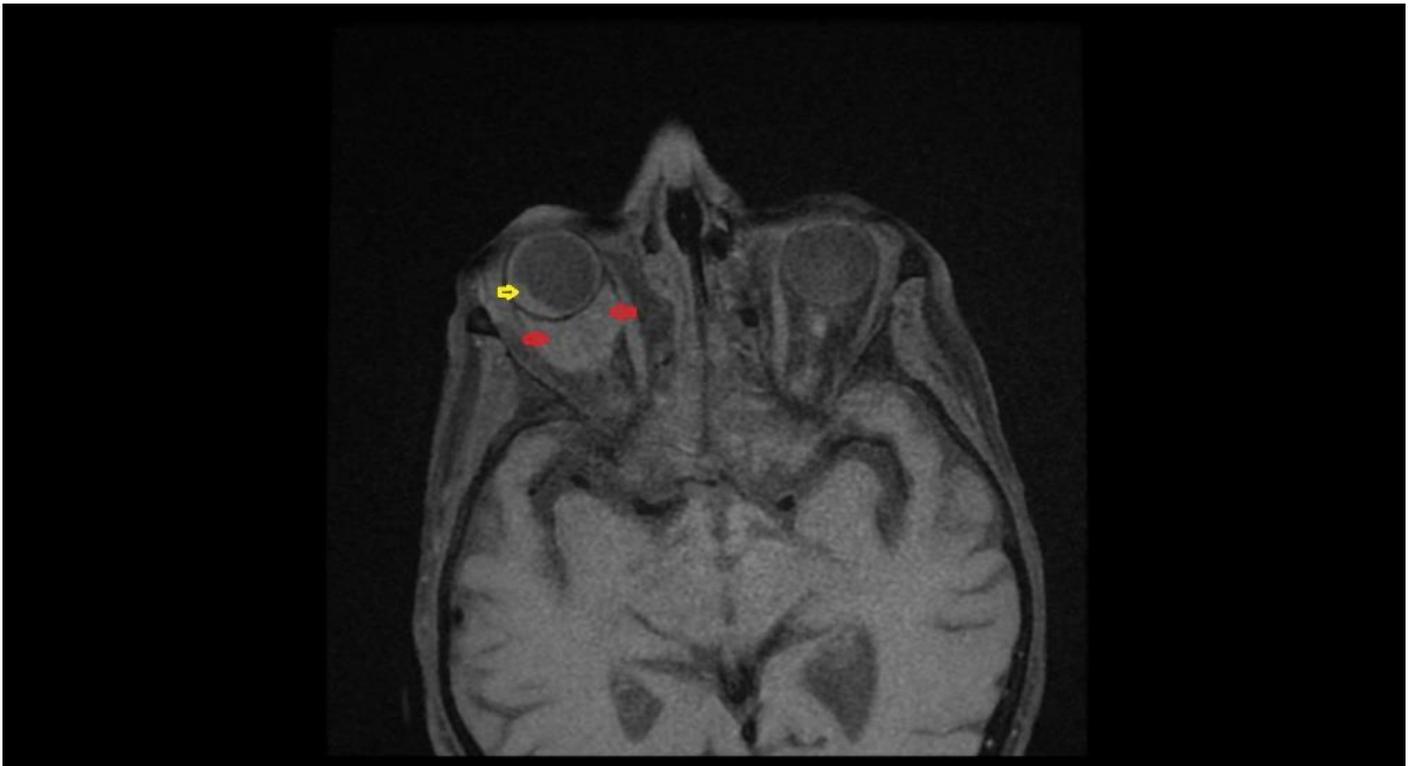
The axial T1-fat suppressed without gadolinium contrast MRI scan of optic nerve sheath meningioma (red arrow) and globe invasion (yellow arrow)
